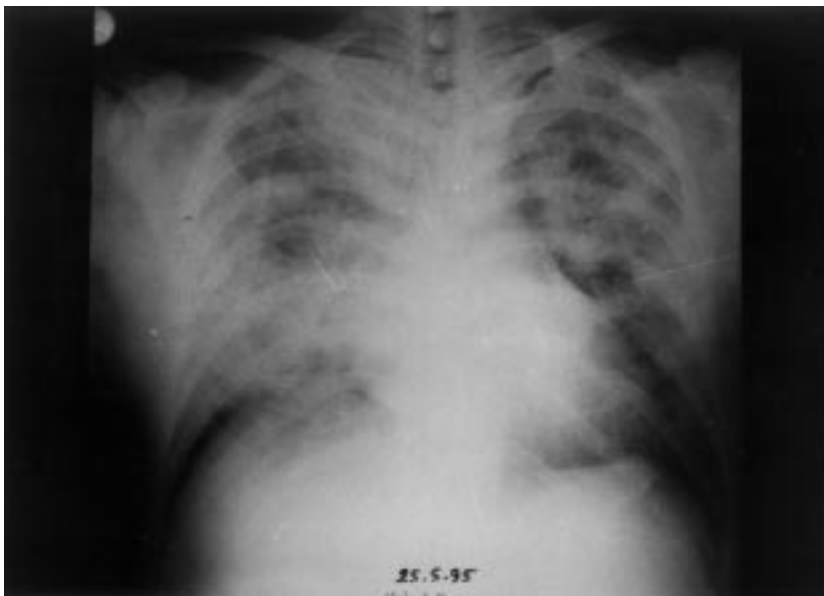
Bilateral infiltrates in the chest x-ray.
